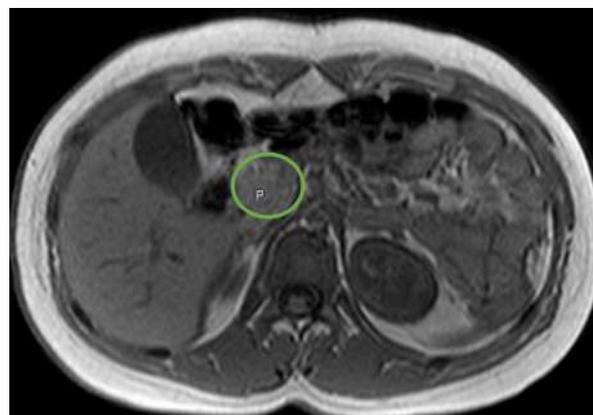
T1-weighted axial magnetic resonance imaging through the upper abdomen showed a normal head of the pancreas (circle). P = pancreas.
